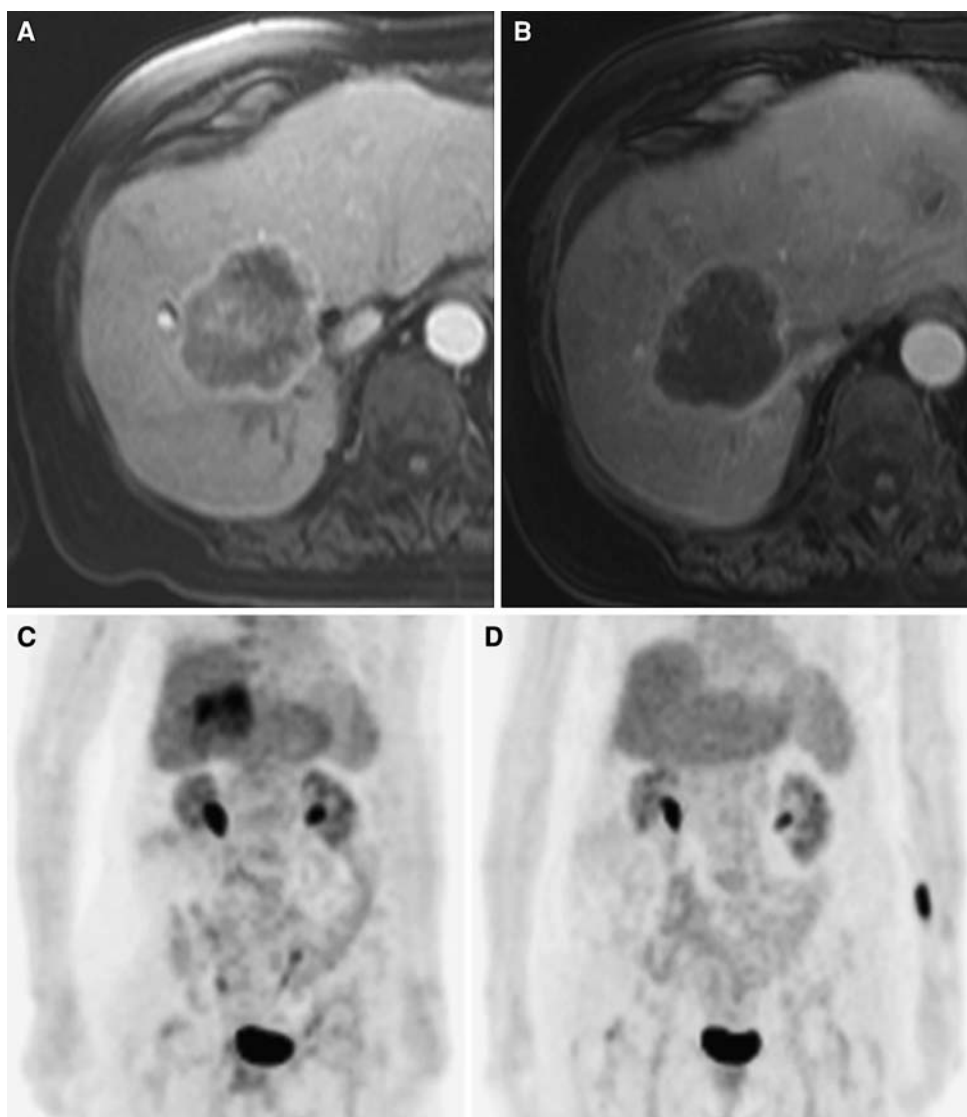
(A) T1-weighted contrast-enhanced MRI demonstrates a ring-enhancing solitary cholangiocarcinoma within hepatic segments 4–8. (B) Following treatment, T1-weighted gadolinium-enhanced MRI demonstrates rim enhancement with near complete necrosis. The cholangiocarcinoma did not decrease in size and represents stable disease by size criteria. (C) Pre-treatment coronal FDG-PET in the same patient as Fig. 6A/B (cholangiocarcinoma) demonstrates a hypermetabolic FDG avid ICC. (D) Post-treatment follow-up PET demonstrates complete resolution with no discernable increased activity in the liver.
